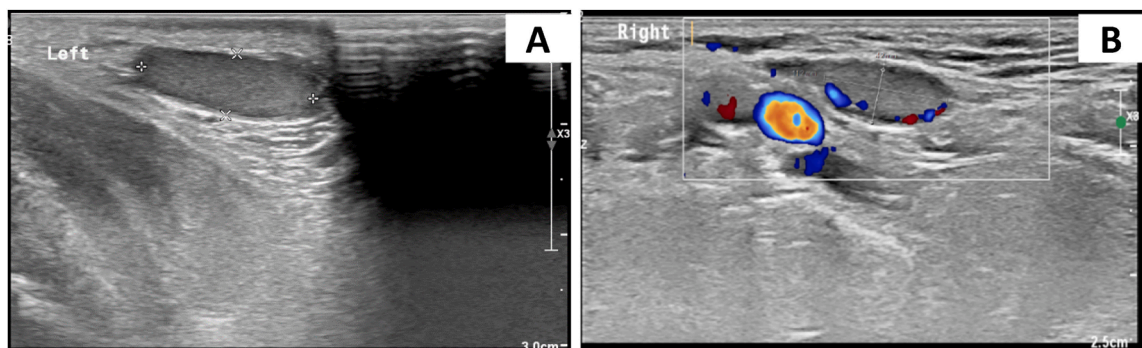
Shows an ultrasound of (A) the left testicle, which is located in the left pre-scrotal region and has normal texture, and (B) the right testicle, which is located high in the right inguinal canal and is small in size (1.2 \* 0.5 cm) and also has normal texture.
